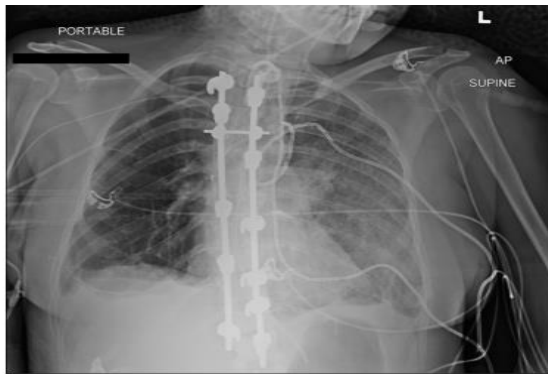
Example of effusion in a chest X-ray image (NIH ChestX-ray14 dataset). Dataset.
